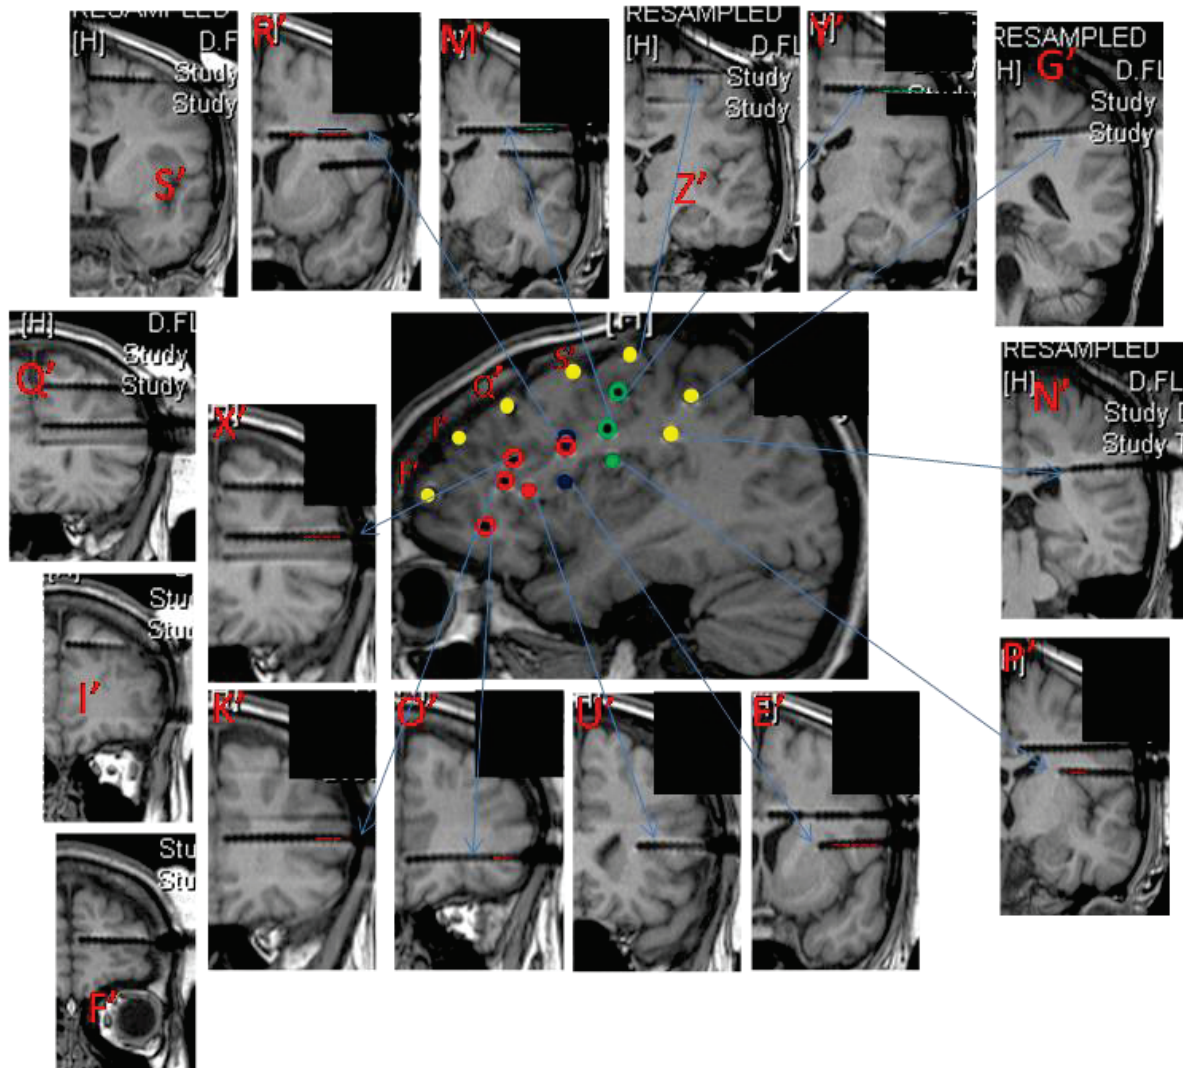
9: Patient 9 MRI with electrodes in place (left hemisphere). Central sagittal image: each insular electrode is represented by a unique colored solid circle; non-insular electrodes are represented by empty circles with the color of each of the insular electrode they are responding to. Yellow solid circles are for non responding electrodes. Peripheral coronal images: a cross-section of each electrode with its name and its responding contacts (responses are indicated by color coded dotted lines, representing the color of the corresponding stimulated insular electrode).
